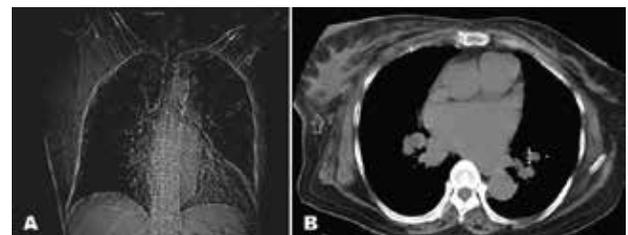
Scout CT shows homogenous haze over the right shoulder and axilla. Fig. 3B-Plain CT displaying right breast edema [white arrow].
